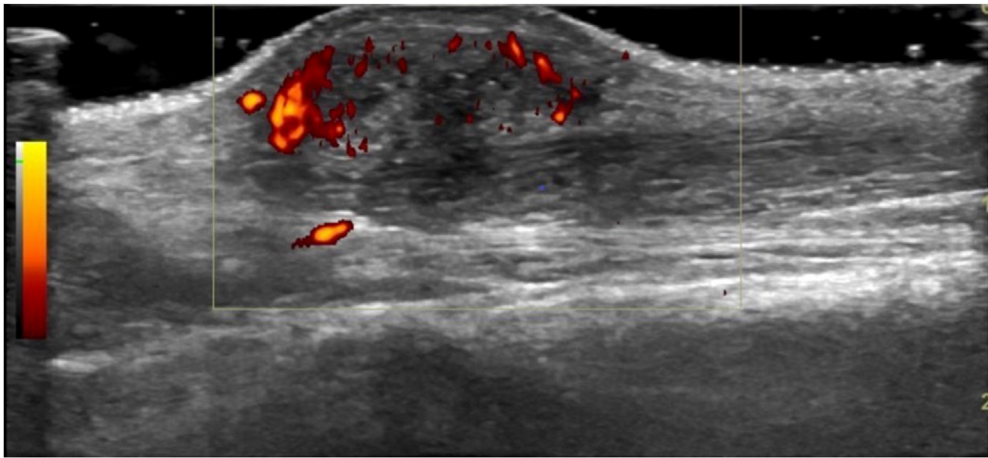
Soft tissue sarcoma. A longitudinal ultrasound view of the right forearm reveals a subcutaneous well-defined, heterogenous lesion with marked internal vascularity that was proven to be a soft tissue sarcoma following biopsy.
